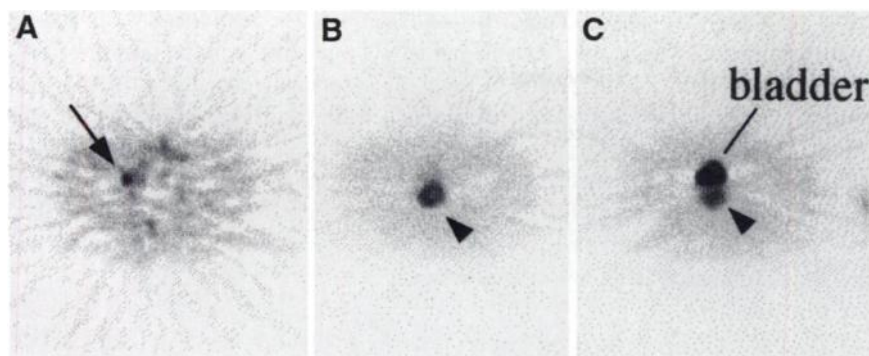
FDG PET images of 41-y-old woman with recurrent cervical cancer and lymph node metastasis (patient 3). Although CT did not detect any lymph node metastasis, PET demonstrates focal intense FDG uptake in right pelvis (arrow, A), in addition to uptake in recurrent tumor (arrowheads, B and C). Recurrent tumor and right intrapelvic lymph node metastasis were confirmed surgically.
